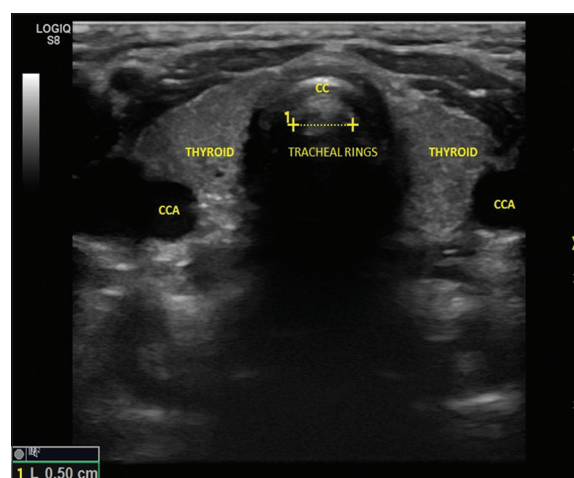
Ultrasonography showing measurement of tracheal diameter. CCA: Common carotid artery, CC: Cricoid cartilage
